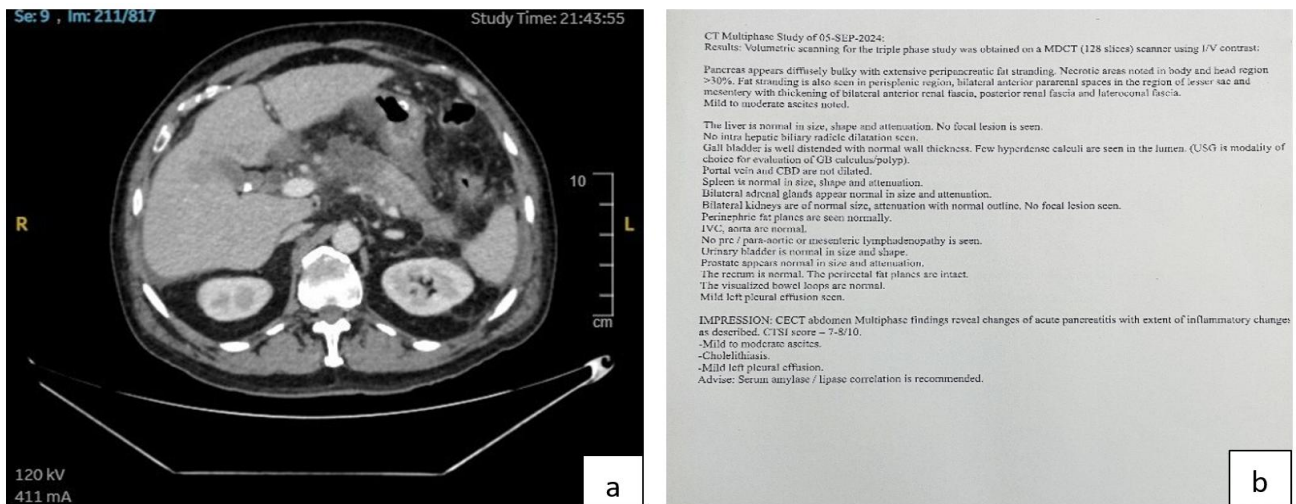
(a) Image, (b) report of contrast enhanced multiphase CT- abdomen.
